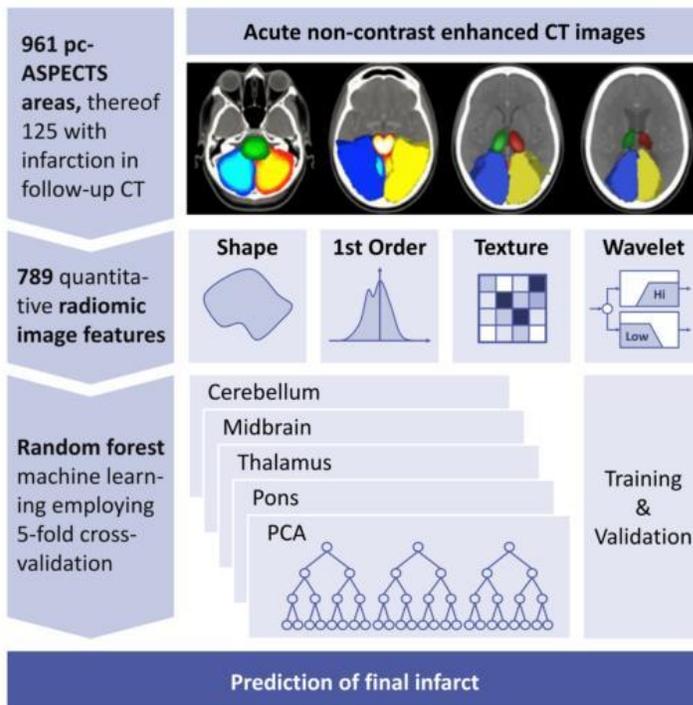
Conceptual overview of proposed random forest machine learning prediction of the final infarct extend based on acute non-contrast enhanced CT images of patients with suspected ischemic posterior circulation stroke. PCA: posterior cerebral artery
